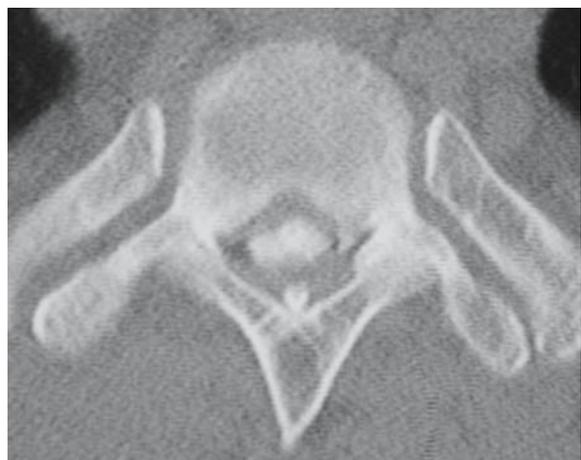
Preoperative computed tomography (CT) myelogram at the level of T1–T2. The spinal cord was compressed by massive OPLL
